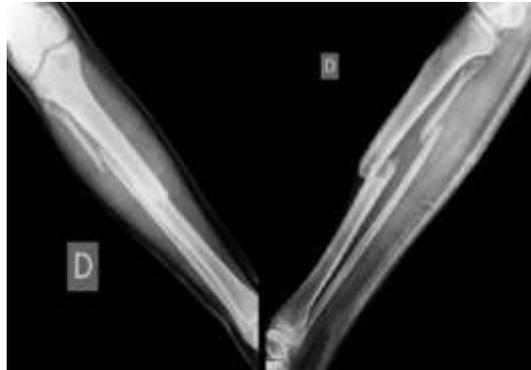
Radiography of the leg showing a mediodiaphyseal fracture of leg bones.
